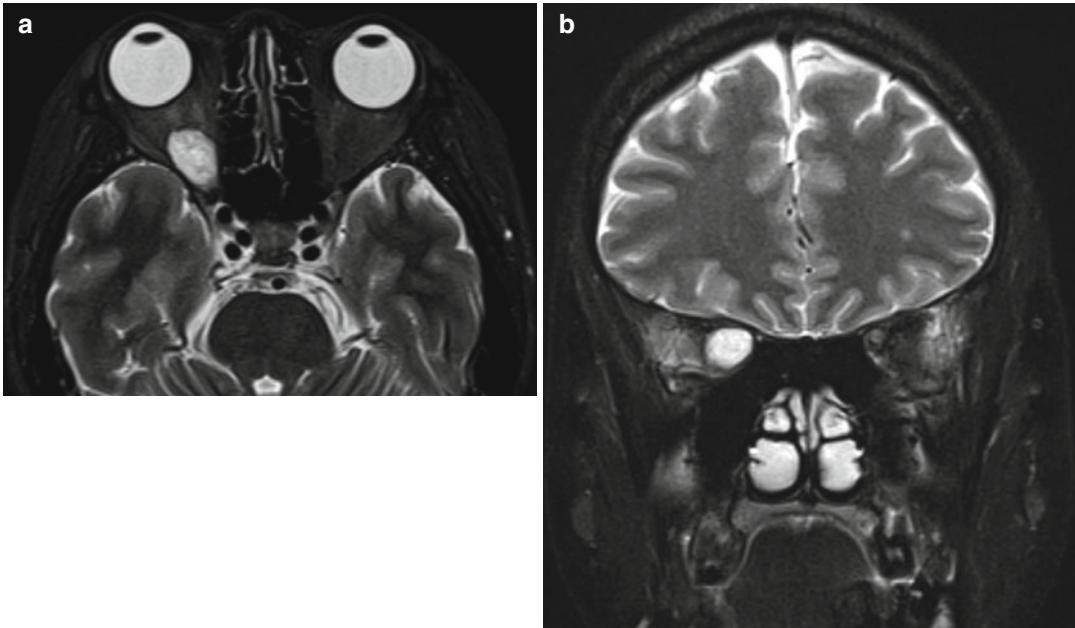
(a) MRI T2-weighted axial scan of patient with right optic apex cavernous venous malformation (cavernous haemangioma): axial scan. (b) MRI T2-weighted
